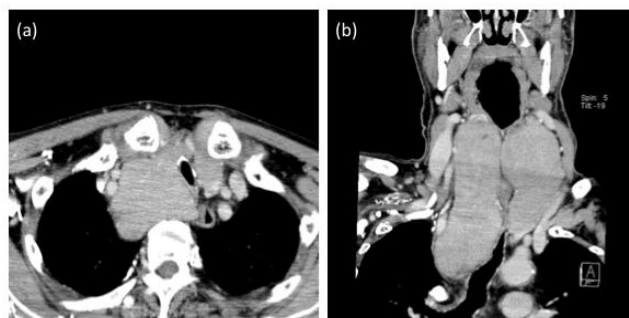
CT of the thyroid in case 2. (a) Horizontal and (b) vertical dislocation was shown.
